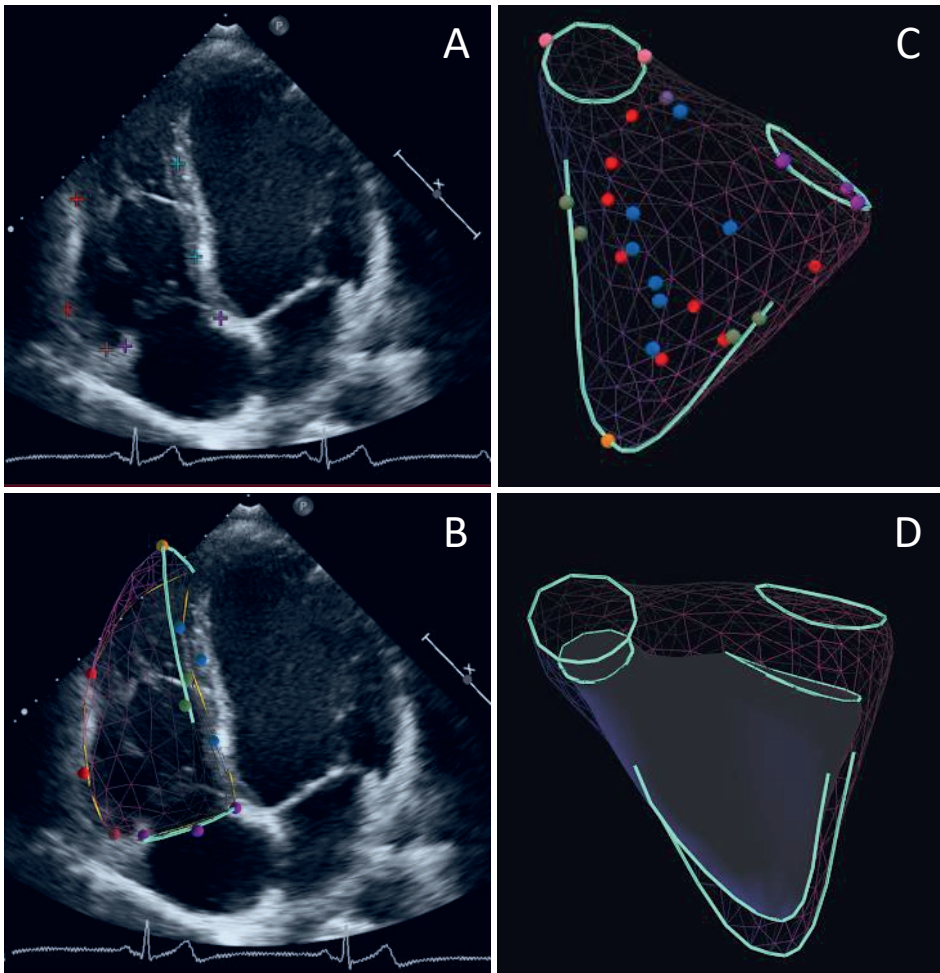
Transthoracic echocardiographic images of the standard apical four-chamber view with points placed to define anatomic landmarks (A) and borders of the three-dimensional model (B). Three-dimensional model of the right ventricle at end-diastole. The two circles represent the position of the tricuspid and pulmonary valves (C). Nested view of the end-diastolic and end-systolic RV model (D). Different colors represent different anatomic landmarks: red = RV endocardium, blue = RV septum, brown = basal bulge, violet = tricuspid annulus, pink = pulmonic annulus, green = RV septal edge, orange = RV apex.
